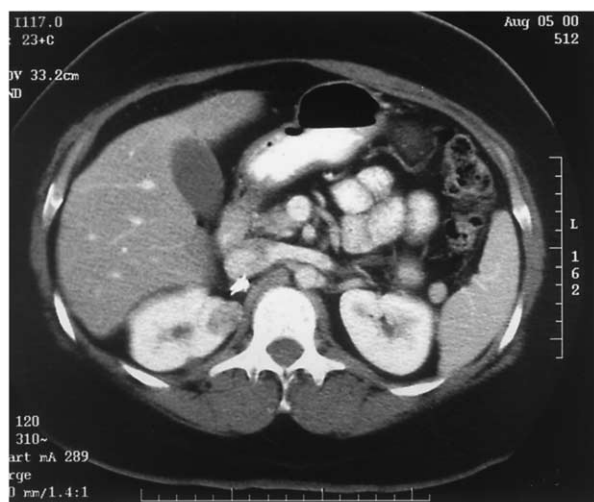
Computed tomography scan of kidneys showing a 3-cm, enhancing, right upper pole renal mass and a more posteriorly located 1-cm cyst. Note metallic clips from previous adrenalectomy.*
